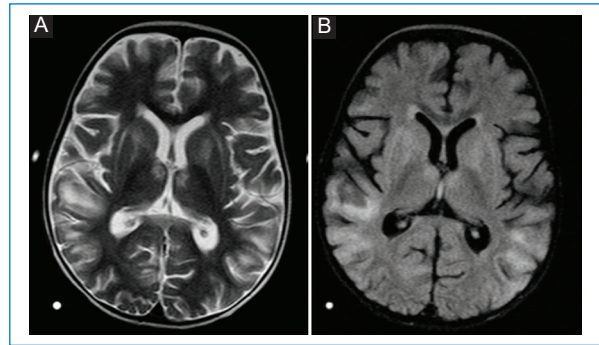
A: T2-weighted imaging axial showing hyperintensities involving bilateral anterior/ventral anterior thalami. B: fluid-attenuated inversion recovery axial showing hyperintensities involving bilateral anterior/ventral anterior thalami.
